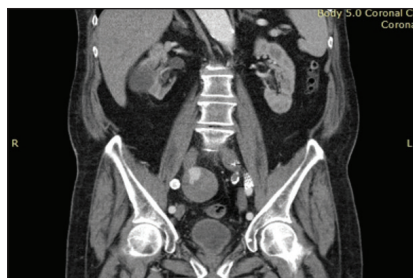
Arterial phase, coronal CTA showing the aneurysmal sac (5.4 cm) and its partial filling with contrast media.
